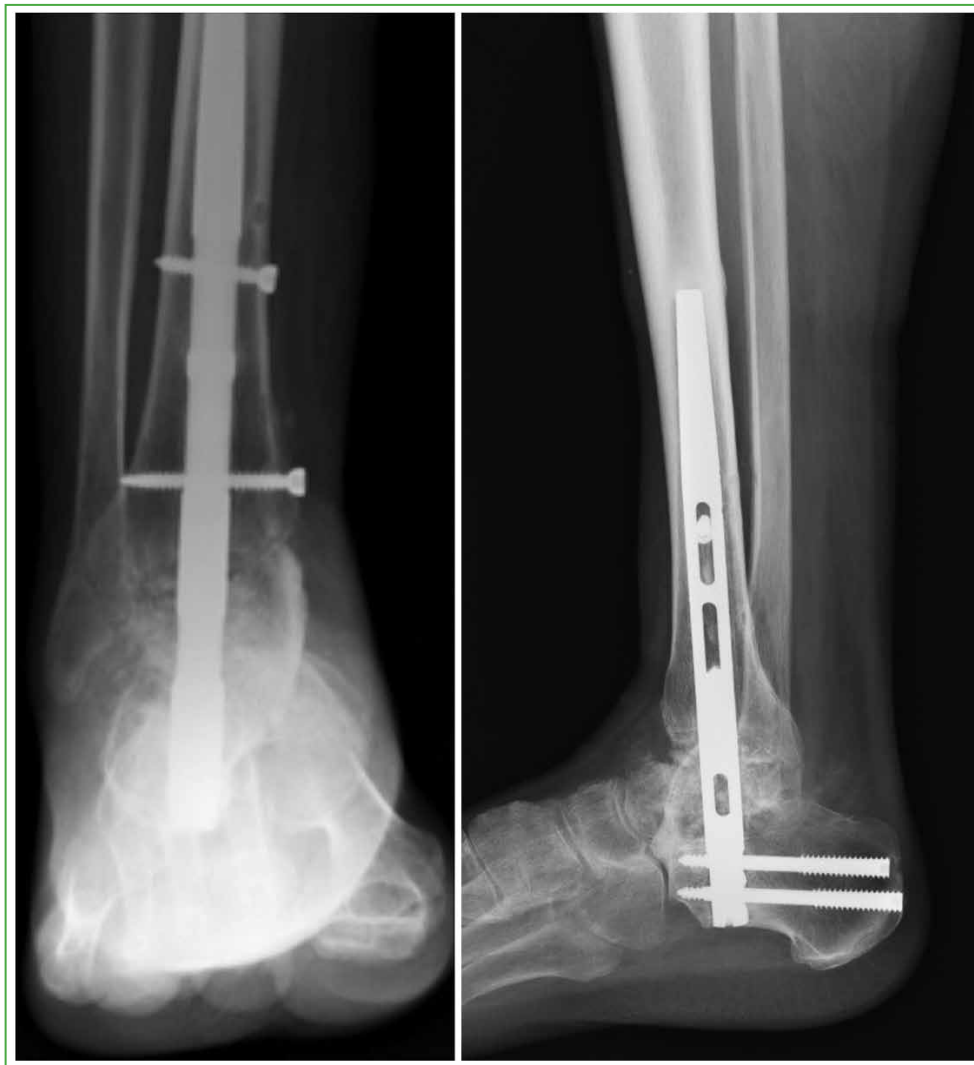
Anteroposterior and lateral ankle radiographs, eight months after the second surgical stage.
